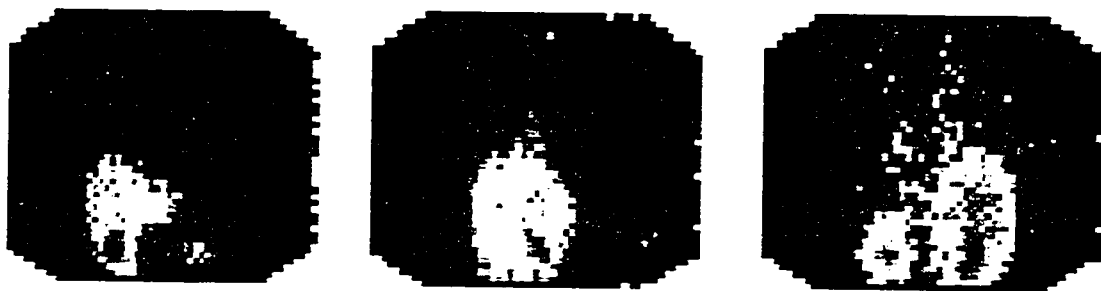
Three representative SPECT image frames (numbers 36, 57 and 72, respectively) of the chest cavity in a 27 year old male volunteer (CV2) following 5.68 mCi ^{123}I -IAZA dose given i.v. during “Bruce” treadmill protocol. Images acquired 1.5 h after the radiopharmaceutical administration.
